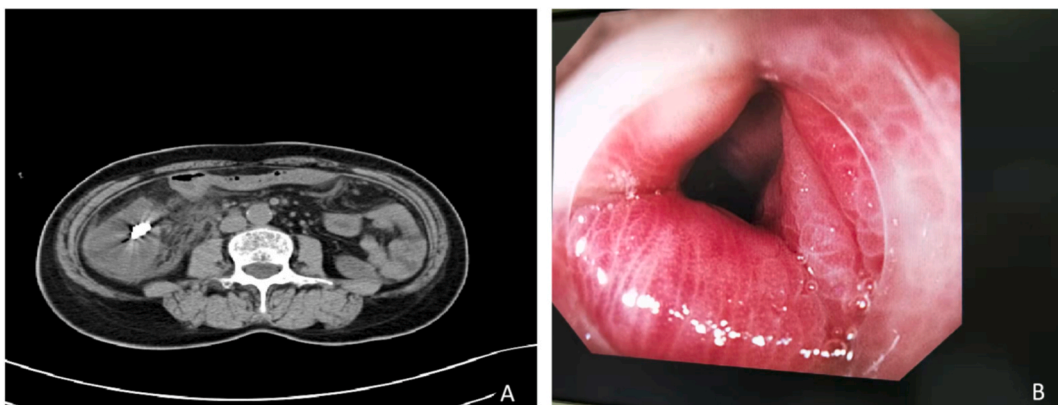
Prior to laparoscopy exploration, we conducted a re-examination using computed tomography (CT) and assess the endoscopic findings. (A) Upon CT re-examination, it was observed that the anterior wall of the ascending colon exhibited distension caused by the presence of gas. Moreover, exudation was detected in the subserosa of the middle segment of the ascending colon. Additionally, a small amount of ascites was noted. (B) An enteroscopy was performed, revealing no evident perforation at the ESD site of the ascending colon, with well-closed metal wound clips, the peripheral intestines had edema and were narrow.
